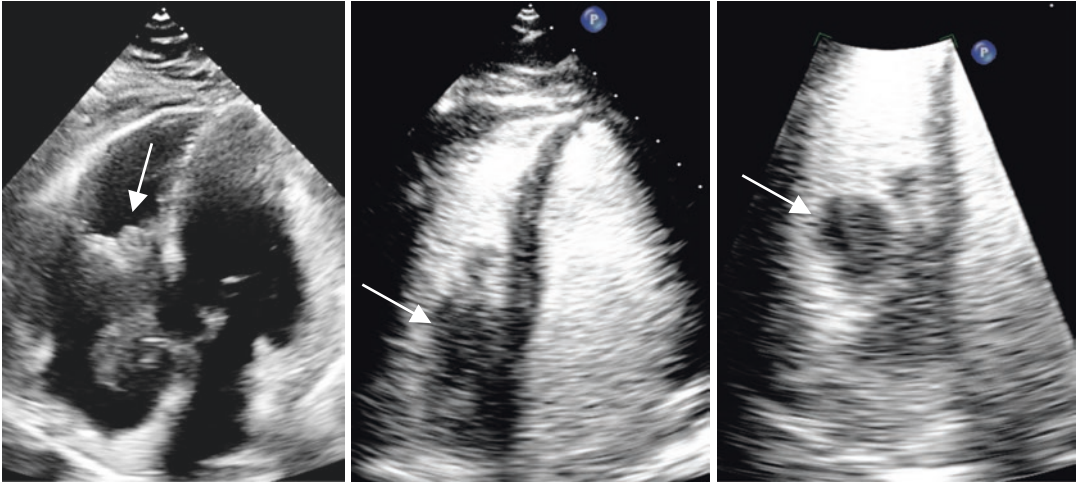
The most likely explanation for the patient's symptoms is a pulmonary embolism that was confirmed on a contrast chest CT. The above echocardiogram images show a large mass prolapsing across the tricuspid valve in the right atrium and ventricle. The use of ultrasound enhancing agents (contrast) clearly demarcates the mass
